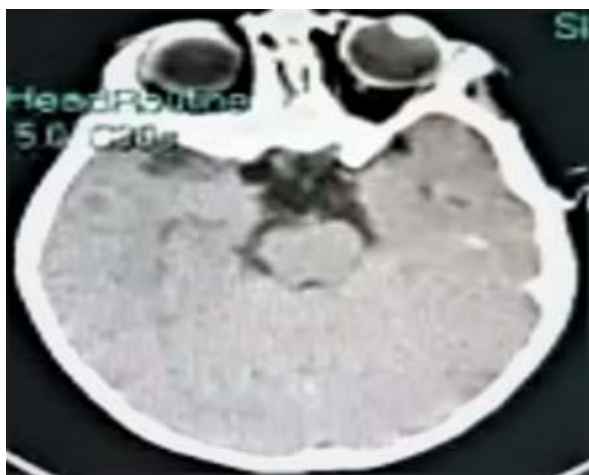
Normal axial view non contrasted CT brain
